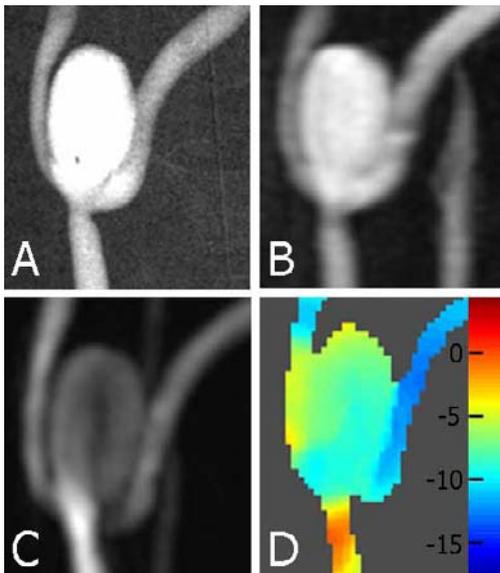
X-ray DSA(A), CE MRA (B), complex difference PC VIPR(C) and pressure(D) images of the aneurysm model. Pressure values are in mmHg.
